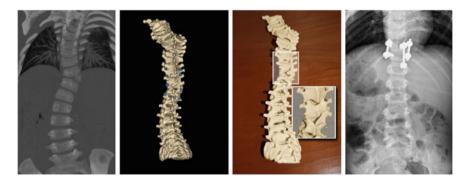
Pre-operative thick maximum intensity projection CT of patient with cervical-thoracic and thoracolumbar congenital scoliosis (*upper-left*), rendering of 3D templating results developed with the spine surgery planning tools (*upper-right*), the physical model (*lower-left*) printed from the plan, and the post-operative radiograph (*lower-right*)
